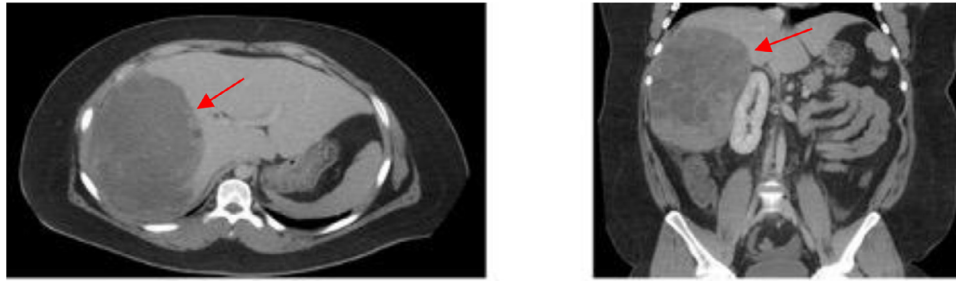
Axial left and Coronal right CT revealing 20.4 x 18.7 x 13.2 cm right hepatic mass (red arrows).
